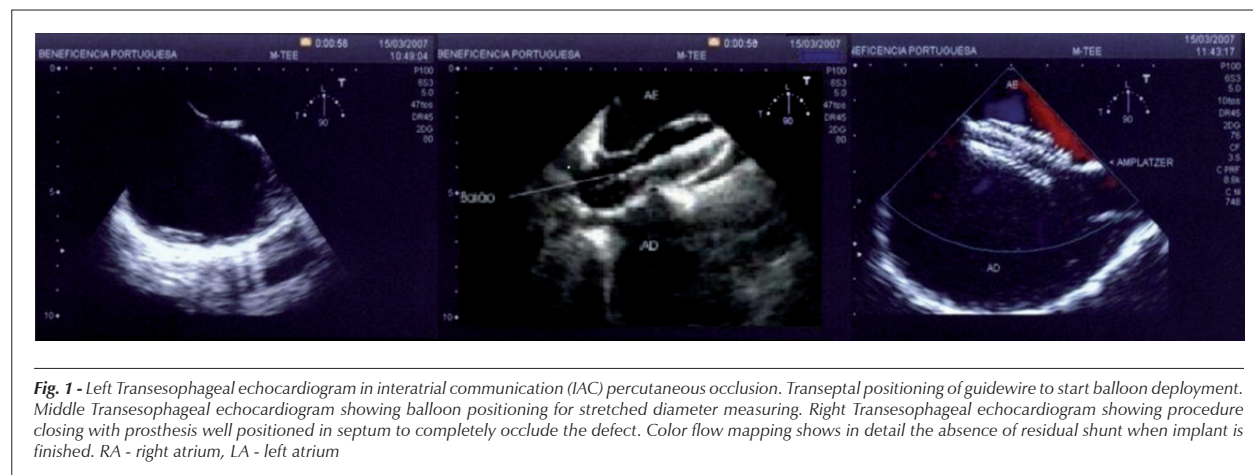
Left Transesophageal echocardiogram in interatrial communication (IAC) percutaneous occlusion. Transeptal positioning of guidewire to start balloon deployment. Middle Transesophageal echocardiogram showing balloon positioning for stretched diameter measuring. Right Transesophageal echocardiogram showing procedure closing with prosthesis well positioned in septum to completely occlude the defect. Color flow mapping shows in detail the absence of residual shunt when implant is finished. RA - right atrium, LA - left atrium
